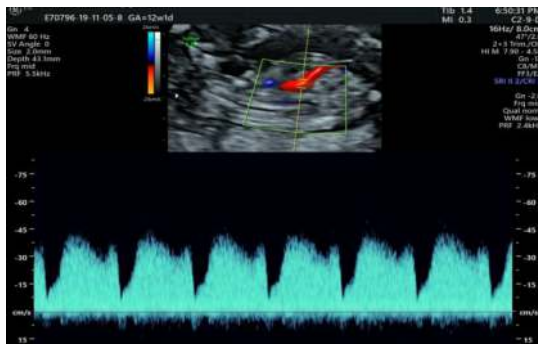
Ductus Venosus Doppler
